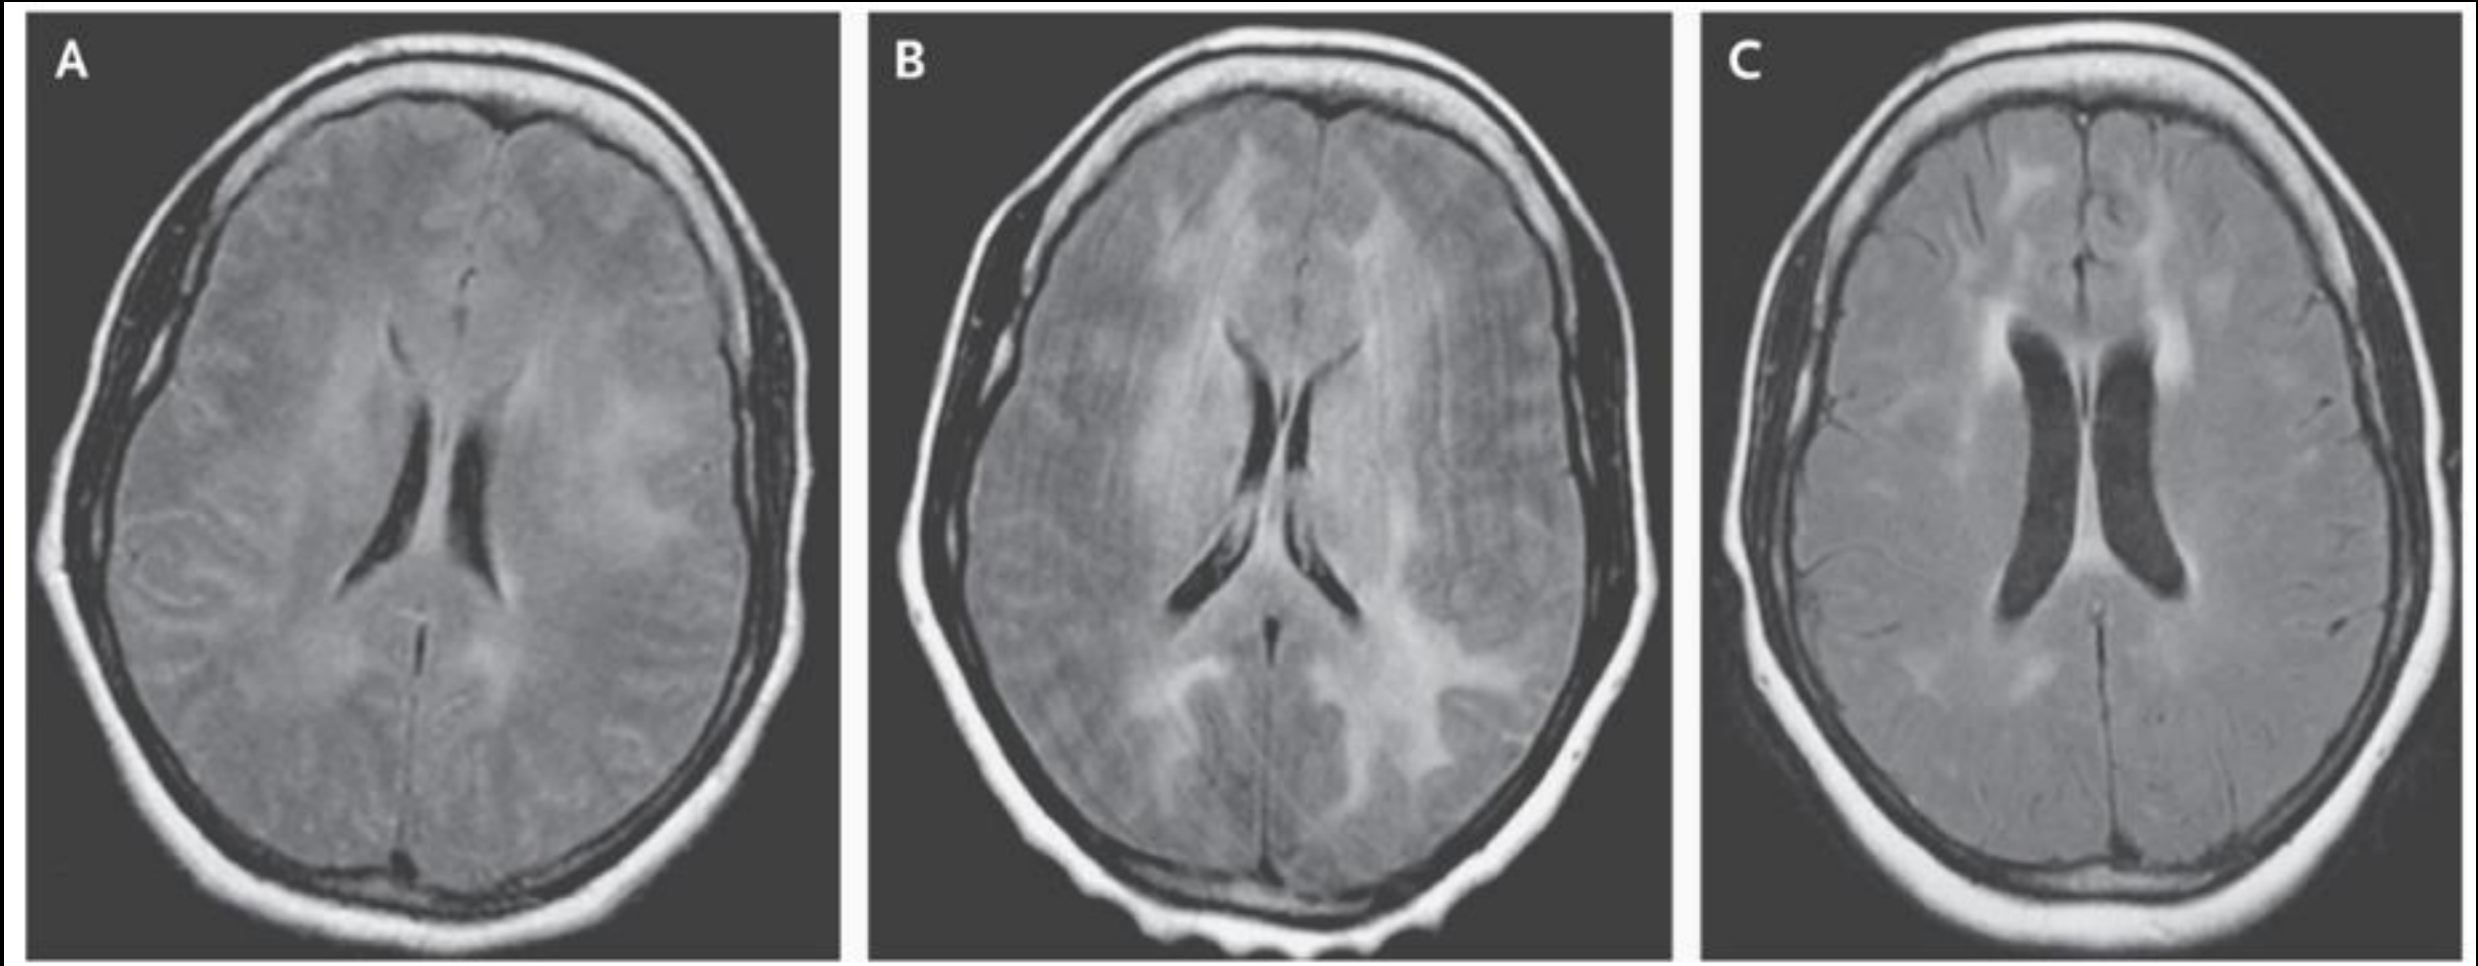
Fluid-attenuated inversion recovery (FLAIR) images obtained from the initial MRI of the brain reveal hyperintense signal abnormalities involving the subcortical and deep white matter at the level of the lateral ventricles (Panel A). FLAIR images from the MRI performed two years later, at the time of the current admission, show a significant progression of the while-matter signal abnormalities (Panel B). FLAIR images obtained 1 year after the initiation of glucocorticoid treatment reveal multifocal regions of hyperintense signal abnormality (Panel C). However, the abnormalities are far less extensive than those seen in the earlier images.
